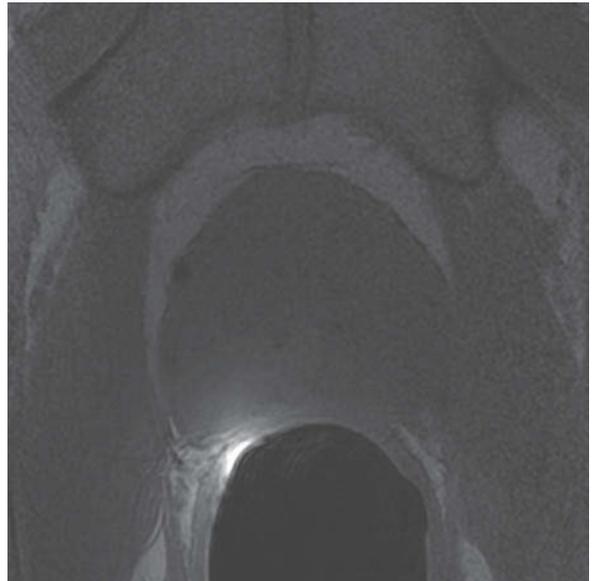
Prostate carcinoma in a 68-year-old male. Axial T2-weighted image (A) at the level of the midgland shows diffuse decreased signal intensity in the left peripheral zone (arrows). Corresponding axial T1-weighted image (B) reveals uniform hypointensity of the prostate gland, indicating that the low T2 signal intensity in the left peripheral zone is due to prostate carcinoma rather than blood products from recent biopsy.
